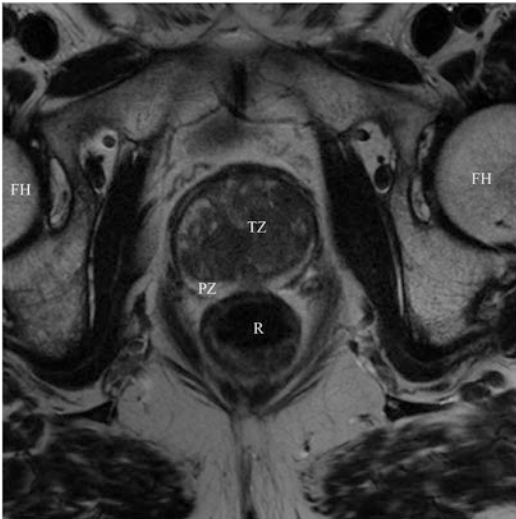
Transversal or axial T2-weighted image of the prostate. *FH* femoral head, *TZ* transition zone of the prostate, *PZ* peripheral zone of the prostate, *R* rectum
